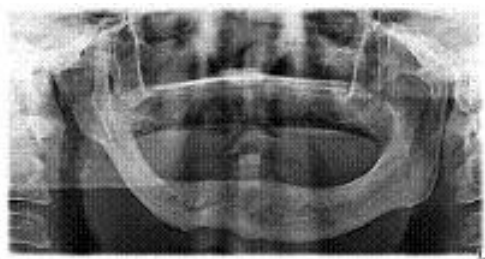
Orthopantomographic (OPG) view.
